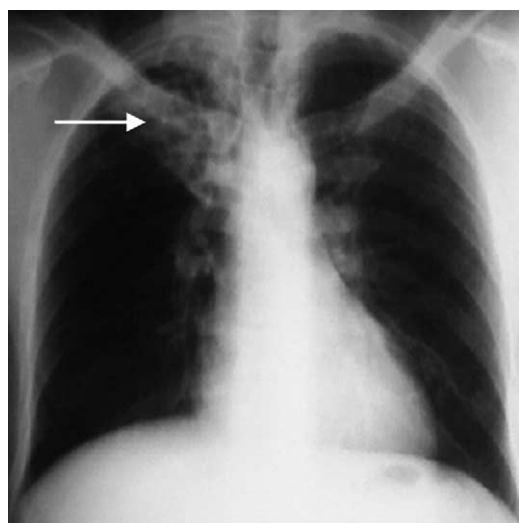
Chest radiograph of an HIV-infected patient with pulmonary TB during HAART. Despite previously advanced immunodeficiency, restoration of immune function during HAART may lead to an increased frequency of typical post-primary apical cavitating disease as shown in this patient at the right lung apex (arrow).
